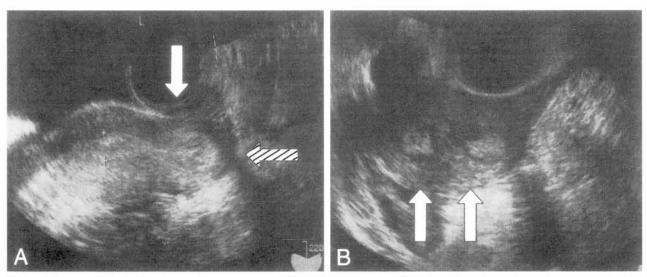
Ultrasound of the uterus and vagina. A: white arrow, transverse vaginal septum; arrow containing oblique line, dead space of the vagina; B: two white arrows indicating two separate endometriums.
